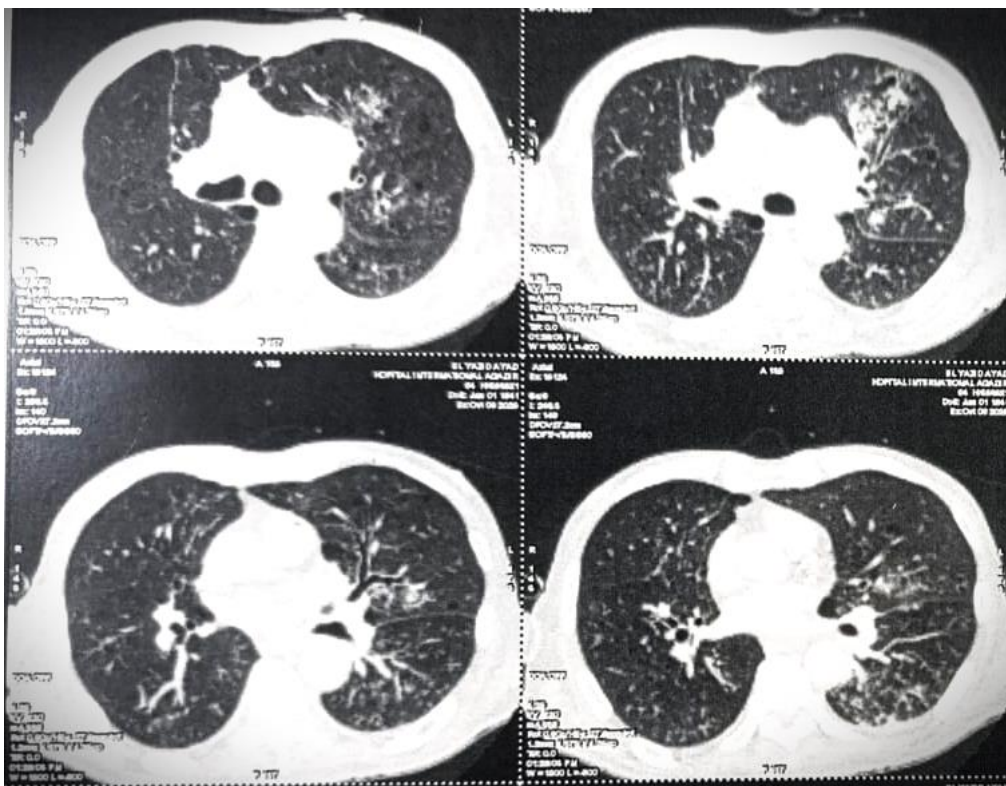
A thoraco-abdomino-pelvic CT scan revealed bilateral pulmonary micronodules and infectious-appearing pulmonary foci, as well as conglomerated mediastinal and peritoneal lymphadenopathy, most consistent with secondary [metastatic] involvement.
